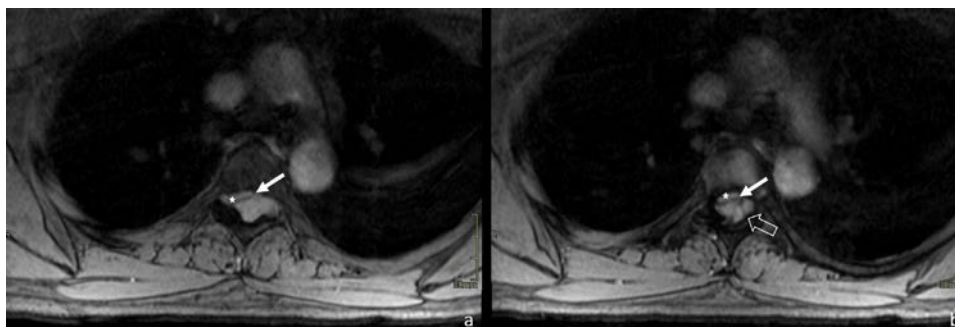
Axial T2-weighted images through the level of the T4-T5 foramen (a) and the T5 vertebral body (b), show the high signal intensity extradural lesion, situated posterolaterally. Compression of the neural elements is present with anteromedial displacement of the dura (seen as a black line - white arrow) and spinal cord (star). Extension through the left T4-T5 intervertebral foramen is seen (a). Multiple serpentine flow voids are identified within the lesion (seen on b - open arrow). No infiltrative features are observed.
